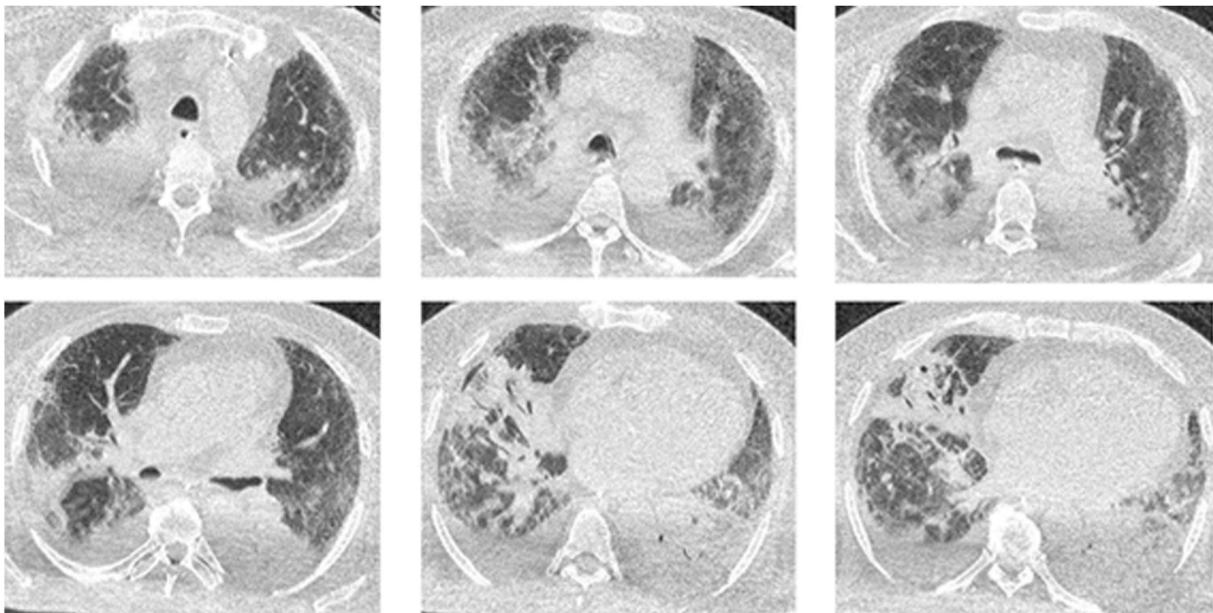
Computed tomography chest on day 69 showing bilateral pleural effusion and increased airspace density with consolidative air bronchogram at the level of both lower lobes. Ground glass subpleural areas persist.
